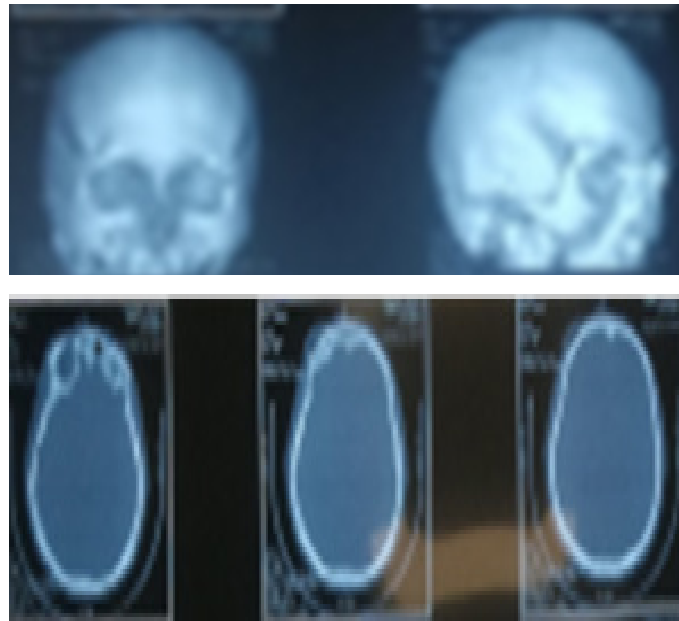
cranial CT scan of periorbital dermoid cyst showed supraorbital bone erosion with remodelling.
